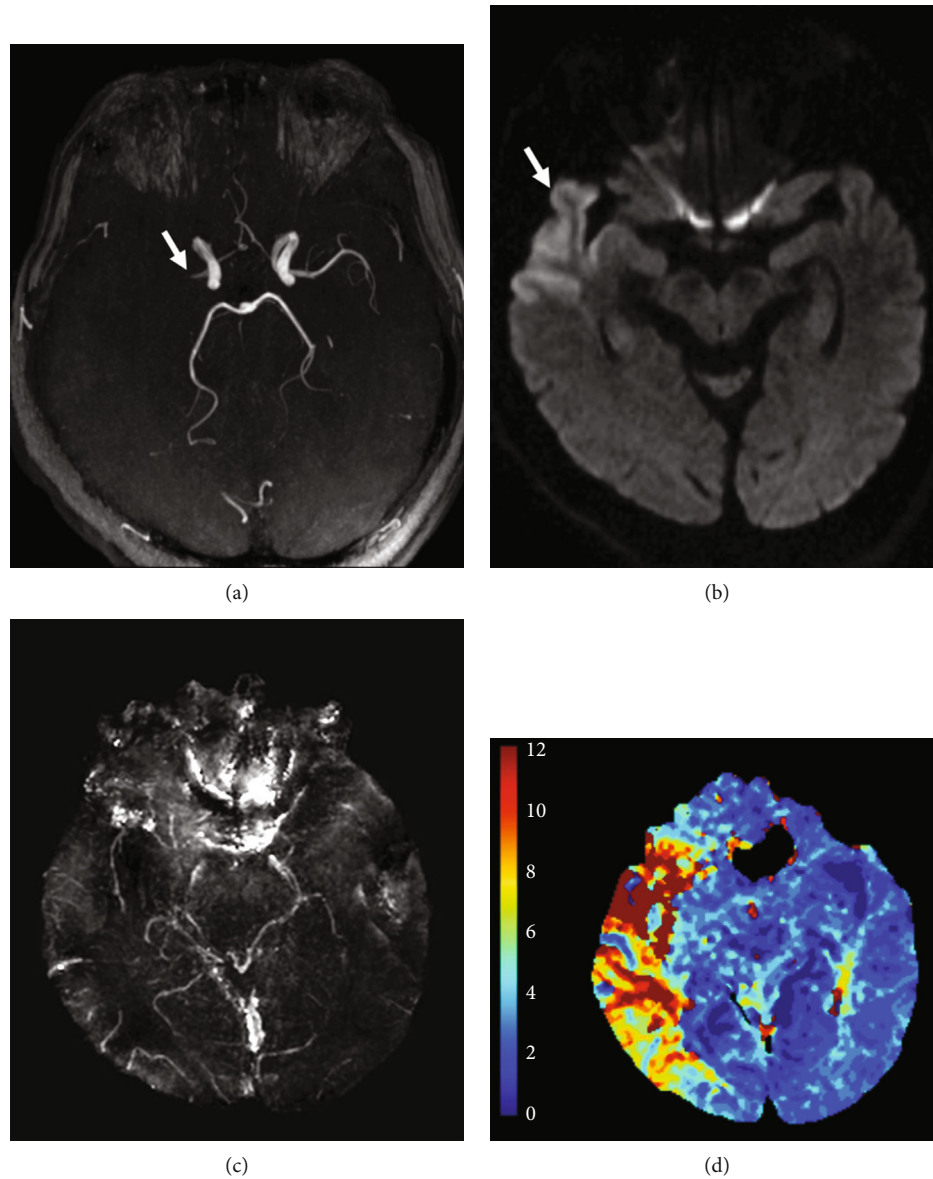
Examples of asymmetrical prominent veins on SWIM with corresponding DWI and time to maximum (Tmax) maps. (a) MR angiography showed occlusion of the right middle cerebral artery. (b) DWI showed a few small acute infarction lesions. (c) SWIM showed the APV region (yellow), which extended beyond the infarct core. The white arrow pointed to the thrombus. (d) Tmax > 6 s map (red and yellow).
